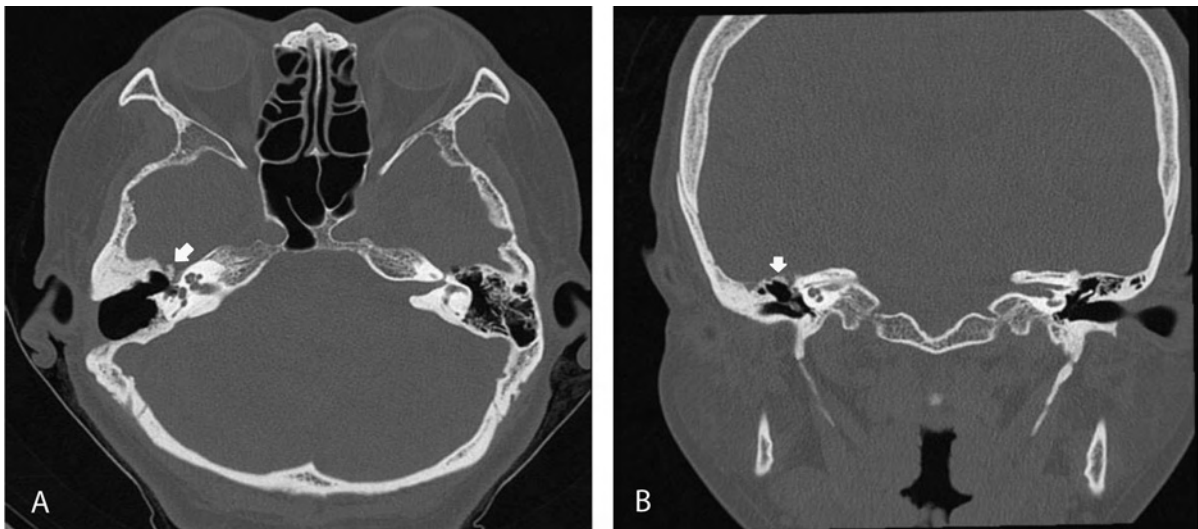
HRCT scan of temporal bone one year post-operative. Axial (A) and coronal (B) images demonstrate a well-sustained anterior wall and roof of epitympanum (arrow). There is no evidence of CSF leak in the tympanic cavity.
